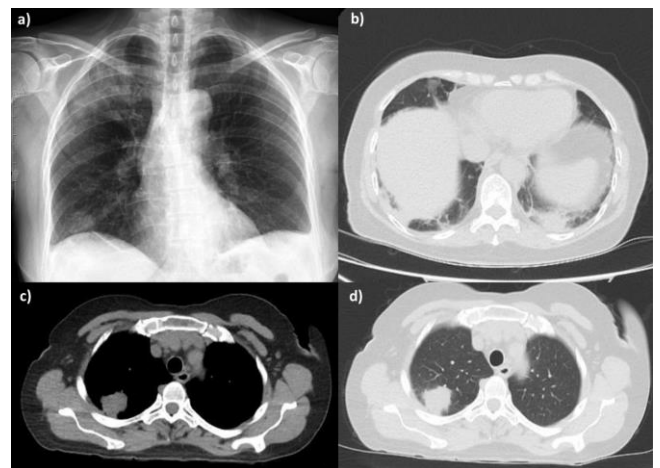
Chest x-ray revealed opacities in the right upper and lower zones (a) Thorax CT revealed focal parenchymal consolidation areas in the basal zones of both lungs (b) Thorax CT of the mediastinal section revealed a mass in the upper zone of the right lung (c) and the lung section (d)
